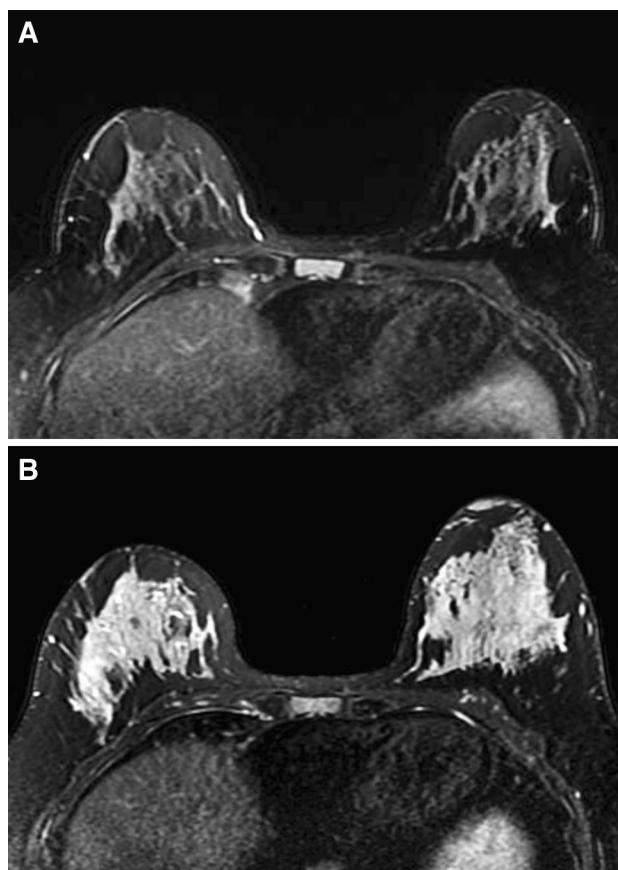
a Axial T2-weighted breast MRI shows appearance of the patient's breast prior to lactation. b Axial T2-weighted MRI shows diffuse increased T2 signal throughout both breasts, compatible with lactational state
